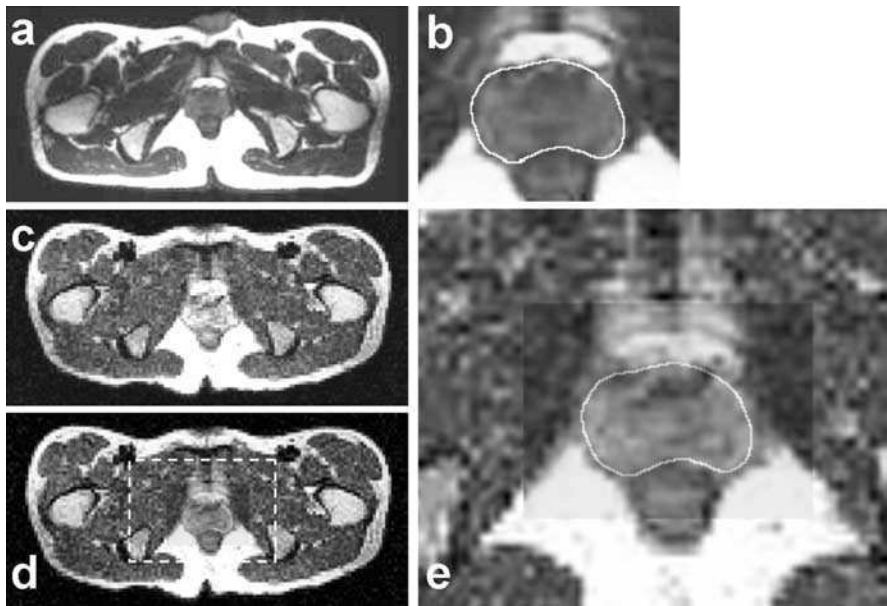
Images after SV registration of actual iMRI slices from a 0.2 T open MR system. Image (a) is a transverse slice from a high-resolution MR volume (1.5 T scanner). The prostate is segmented and magnified in image (b). Image (c) is the actual iMRI slice (0.2 T scanner). Images (c) and (b) are displayed together in an overlay in image (d), and the white rectangular region is magnified in image (e). The segmented prostate boundary from the high resolution MR image is copied to the actual iMRI image where it closely matches the prostate in the actual iMRI image slice indicating excellent registration.
